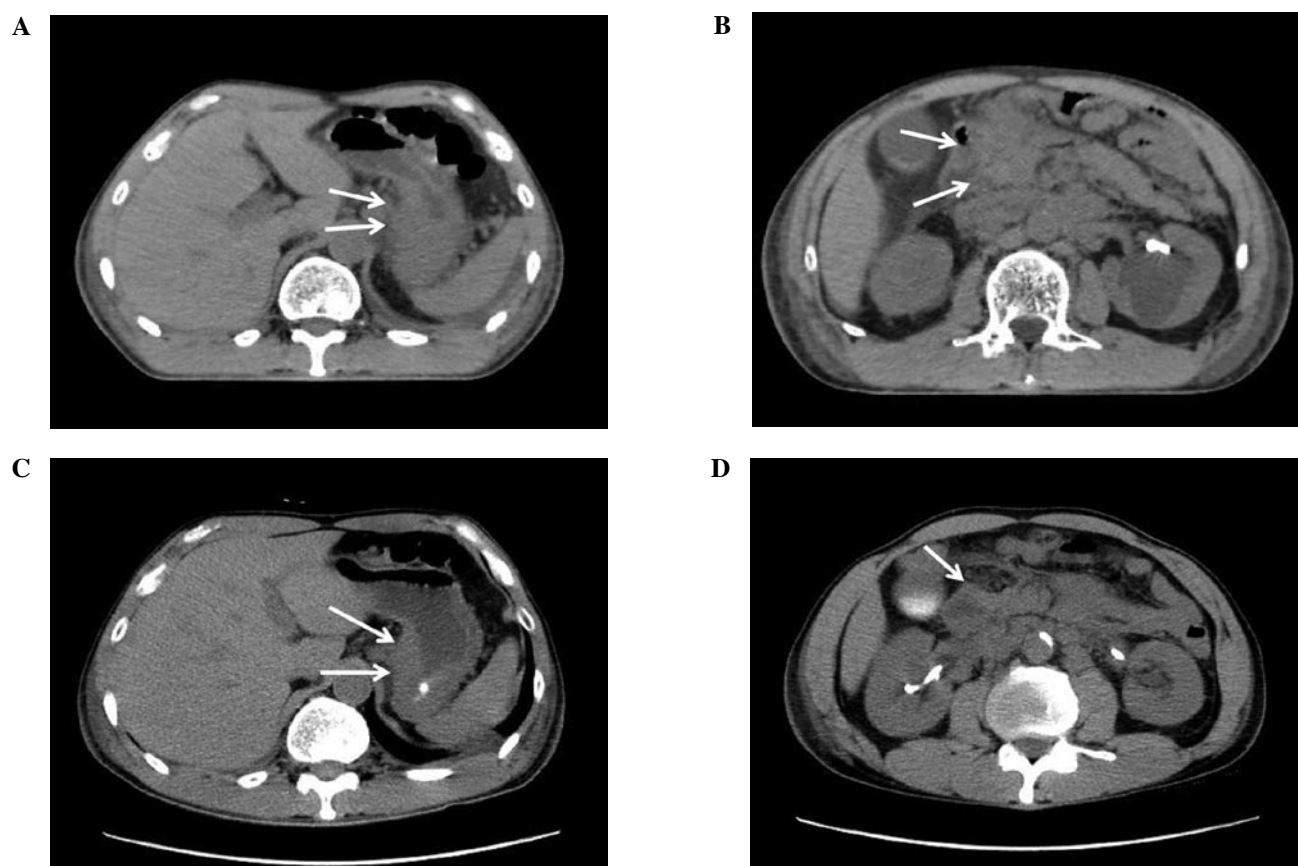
(A) Abdominal CT prior to chemoradiotherapy shows the wall thickness of the stomach. (B) A large tumor comprising a primary lesion, as well as regional lymph nodes are shown. (C) After chemoradiotherapy, the wall thickness of the stomach improved. (D) The size of the large tumor decreased. The clinical response was evaluated as PR.
